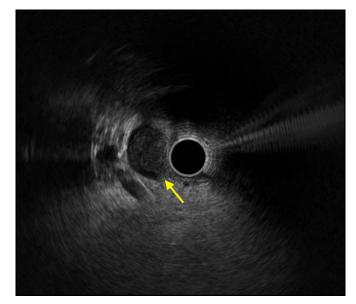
EUS. Arrow showing 1.5-cm hypoechoic CBD tumor. CBD, common bile duct; EUS, endoscopic ultrasound.
